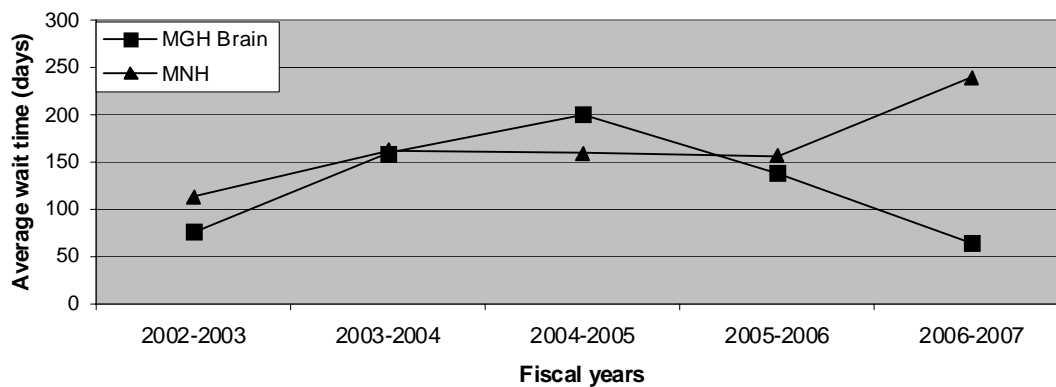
MRI variation (non-contrast) in wait times by period 2002-2007
